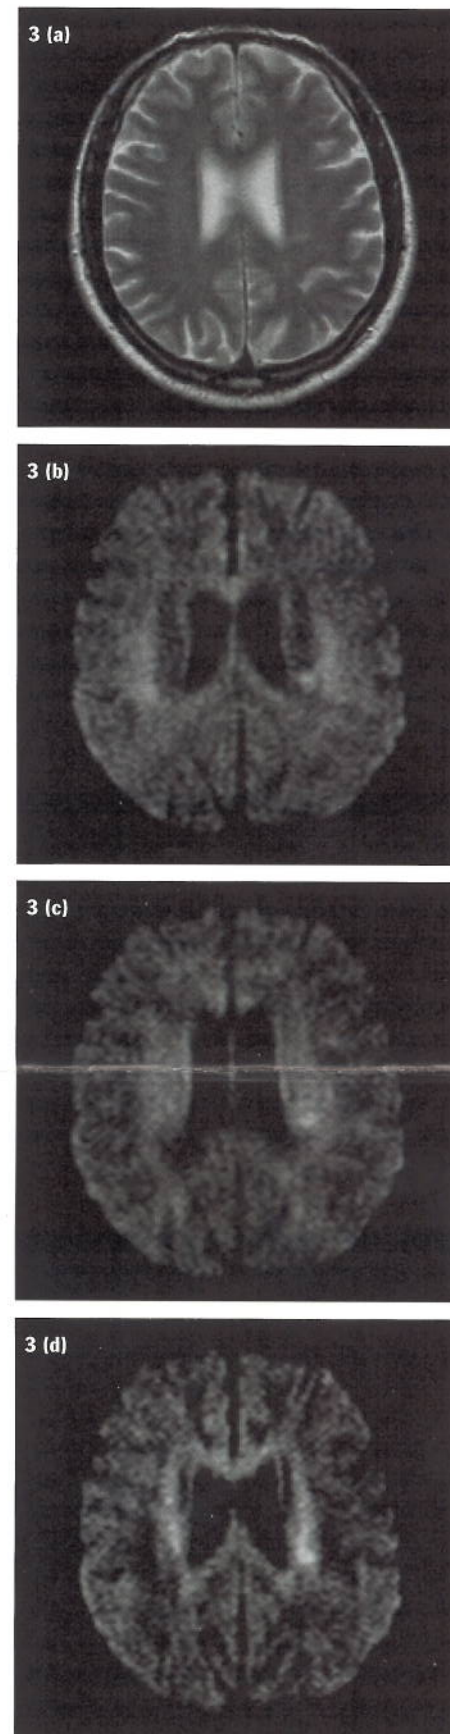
(a) Negative T_2 -weighted MRI imaged at <24 hours after onset of symptoms (exact time unknown) was also negative on CT. Positive diffusion-weighted images of same patient are encoded in three separate directions to demonstrate the importance of viewing all three images to distinguish lesions from anisotropy of brain tissues: (b) slice-select, (c) readout, (d) phase-encoding directions.
